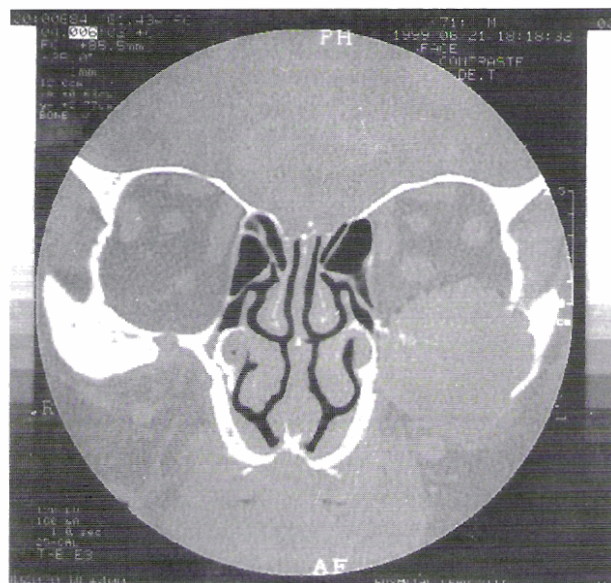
Coronal CT scan showing the lesion (orbit size).
